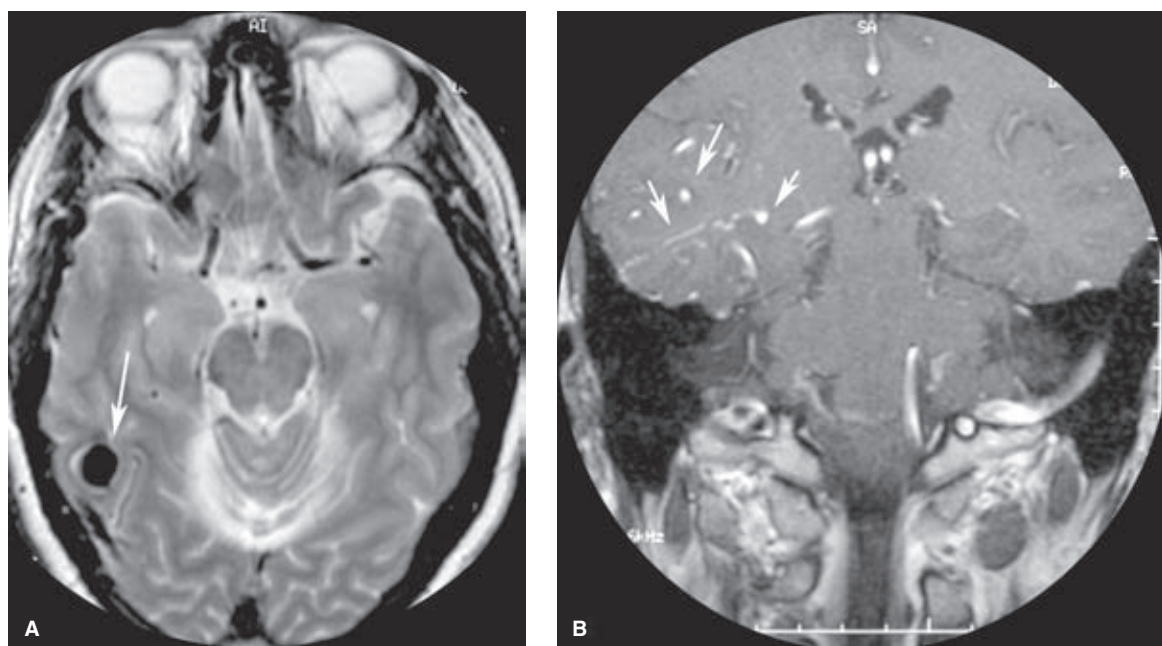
(A–H) A dural vascular malformation with parenchymal venous hypertension. An elderly patient presented with right hemispheric and subarachnoid hemorrhage. A T2-weighted MRI (A) and contrast-enhanced T1 coronal image (B) show a large aneurysmal flow void within the right temporo-occipital area and distension of intraparenchymal vessels through the region (arrows). A right common carotid arteriogram (C) and right external carotid arteriogram (D) demonstrate that the offending lesion is a DAVM with arterial feeders from the right middle meningeal artery and right occipital artery.
